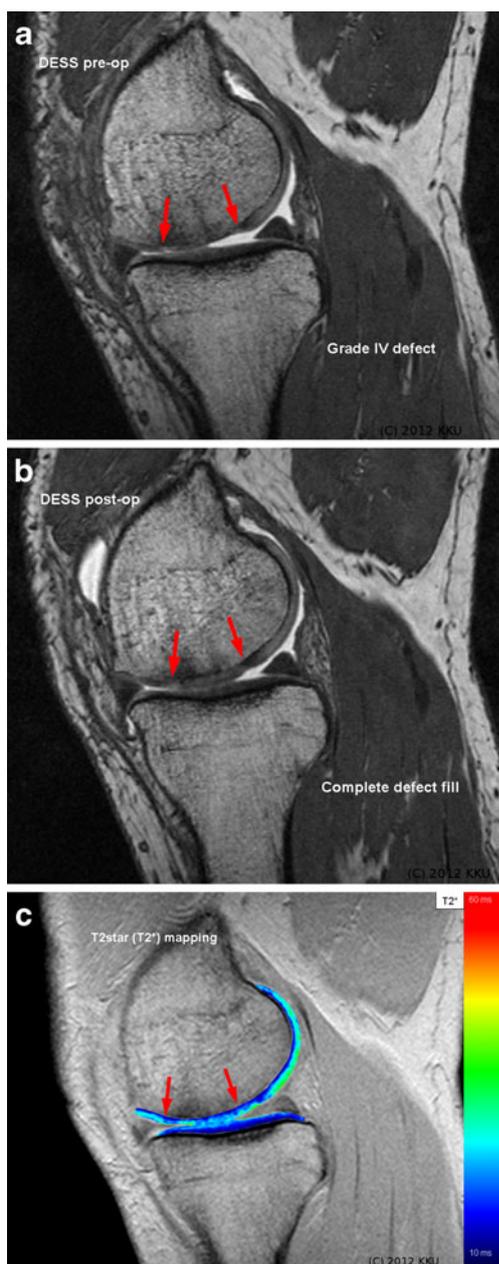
Example case of a 51-year-old male patient (no. 2 in Table 1) undergoing autologous collagen-induced chondrogenesis (ACIC). The 3D DESS MRI shows the preoperative ICRS grade IV defect on the medial femoral condyle (a), which is completely filled with repair tissue 12 months after the arthroscopic ACIC procedure (b). c On the T2* map, one can observe similar T2* values in the cartilage repair tissue (34 ± 6 ms) in comparison to the surrounding weight-bearing native cartilage (36 ± 6 ms)
